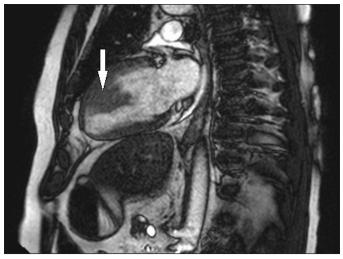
Cardiac MRI showing a left ventricular mass (white arrow).
